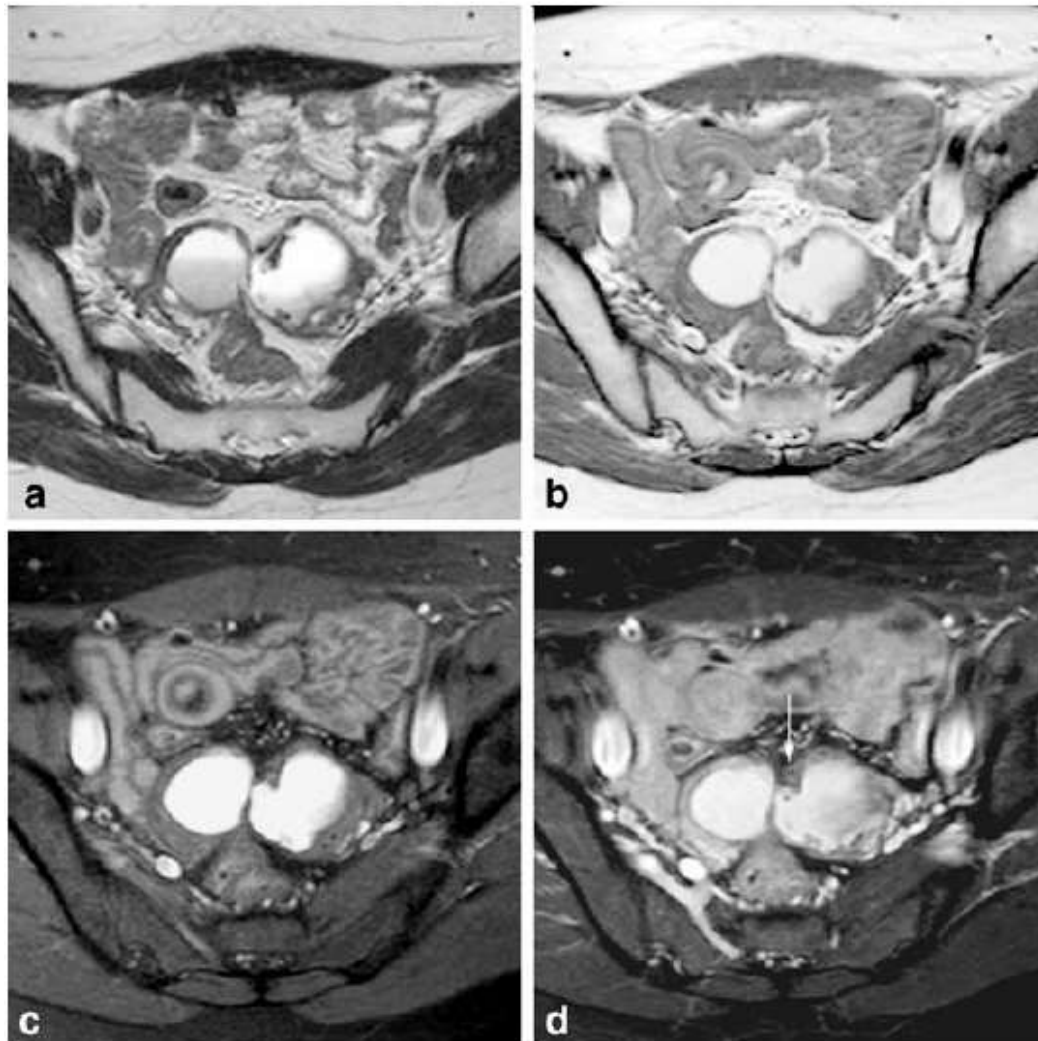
MRI of the pelvis in a 29-year-old woman with dysmenorrhea. A. Axial T2-weighted image demonstrates bilateral ovarian cysts with an upper hyperintense content and indistinct internal lesions margin suggestive of intraovarian adhesions (“kissing ovaries”). B-D. The same image level as in A at different T1-weighted sequences: native T1-weighted (B), fat suppressed T1-weighted (C), and after intravenous contrast enhancement and fat suppression (D). The Ty hyperintense content of both cysts persists after fat suppression while the irregular wall of the cyst does not demonstrate enhancement after intravenous contrast injection (*arrow*). Pathology confirmed the diagnosis of endometriosis. Extracted from (18).
